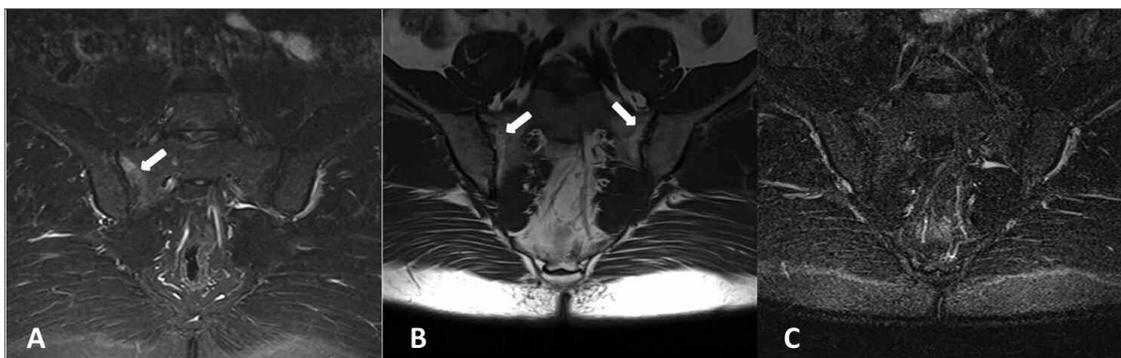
1A) Fat suppressed coronal T2 weighted MRI shows bone marrow edema on sacral surface of right sacroiliac joint indicating active inflammation (arrow).
